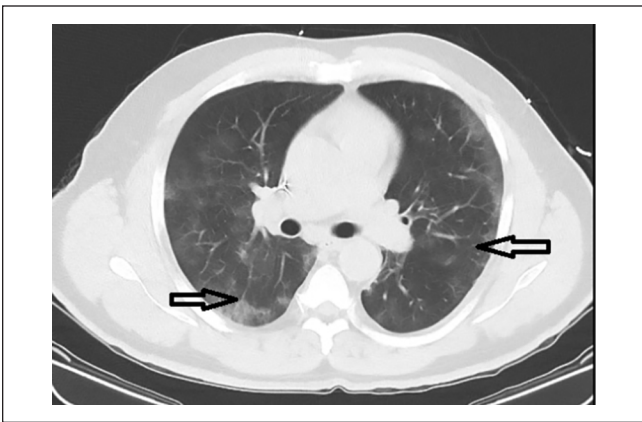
Computed tomography of the chest without contrast showing patchy bilateral ground-glass opacities in the periphery of both lungs.
